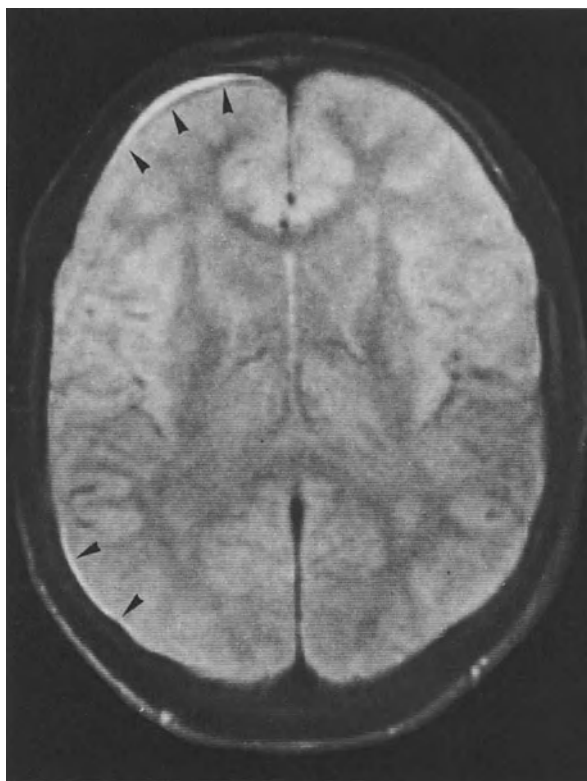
a-c. MRI appearance of normal meninges. a On moderately T2-WI the CSF has a somewhat lower signal intensity than the brain tissue. Especially the gyri cannot be delineated clearly from the cortex. The space between cortex and inner surface of the skull appears homogeneous; meningeal structures are not visible. b On unenhanced T1-WI the external CSF space appears dark. In this space a linear structure running parallel to the inner surface of the skull can be differentiated. The signal intensity of this structure is equivalent to the general parenchymal signal intensity. c After administration of 0.1 mmol Gd-DTPA/kg BW an increase in the signal intensity of this meningeal structure is a regular and normal finding
